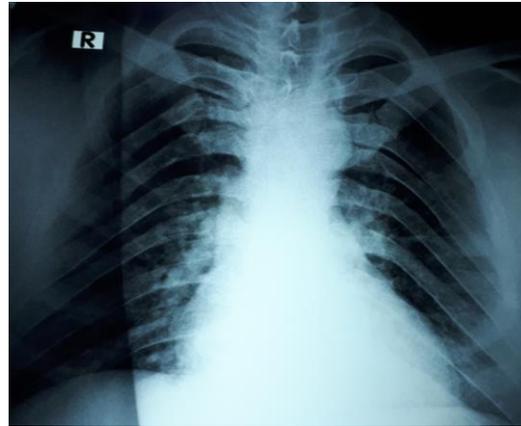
Chest x-ray revealed a bifid rib
